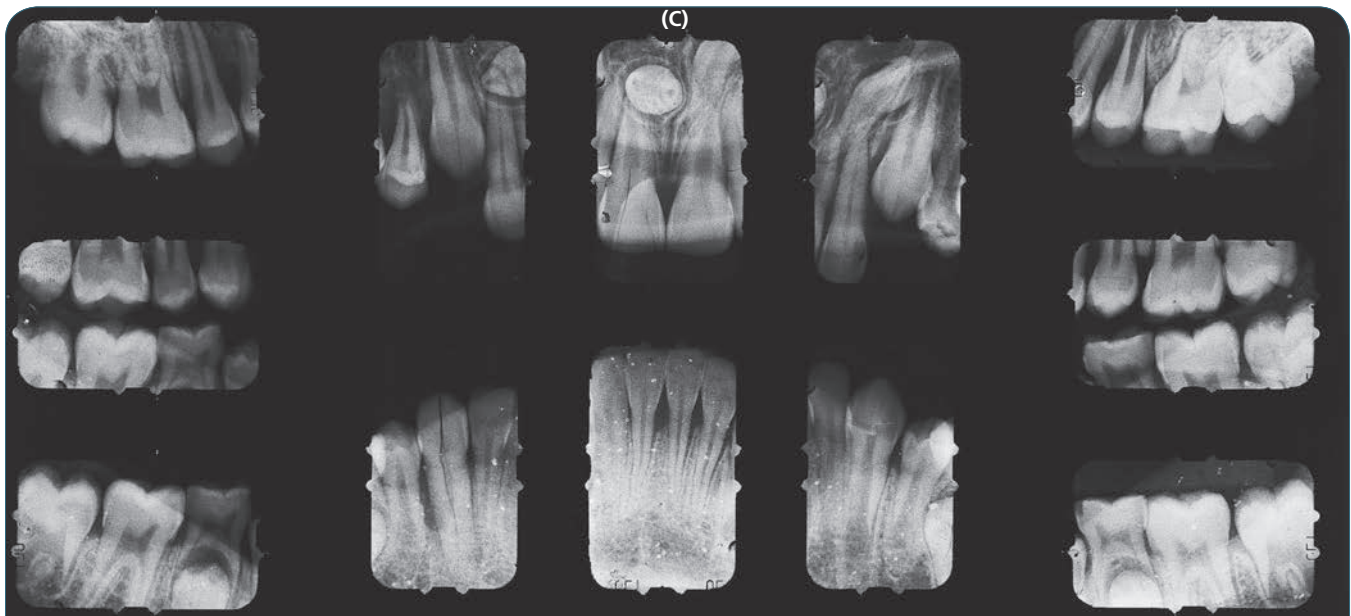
(continued) (C) Pedodontic full mouth survey of a child 6 to 12 years old includes two bite-wings, six anterior incisors, and four posterior periapicals.
